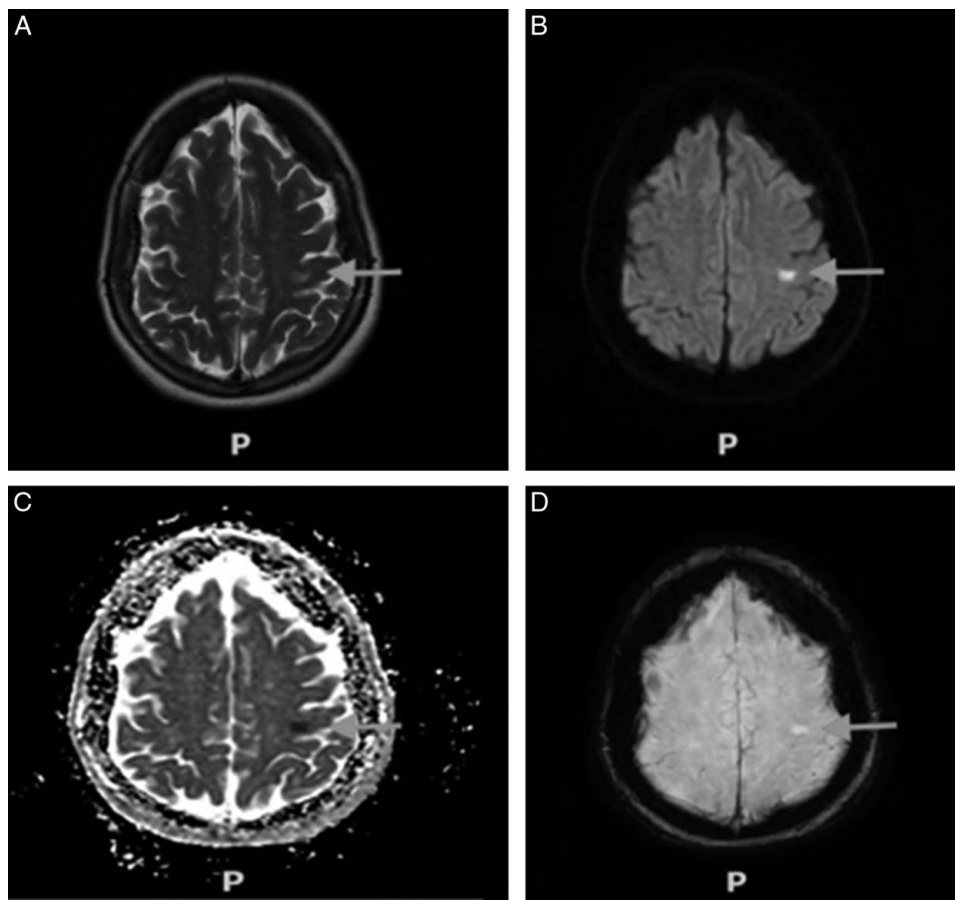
T2 axial view (A), diffusion-weighted imaging (B), apparent diffusion coefficient (C), and three-dimensional susceptibility-weighted angiography (D) MRI of the brain show an infarct in the left medial precentral gyrus (arrows).
